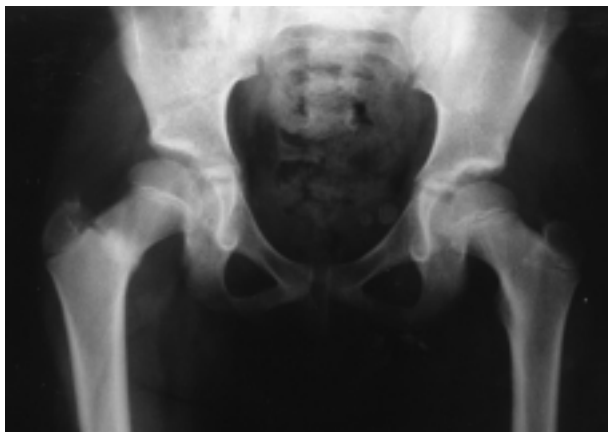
Radiograph showing an advanced fatigue fracture of the right femoral neck.
